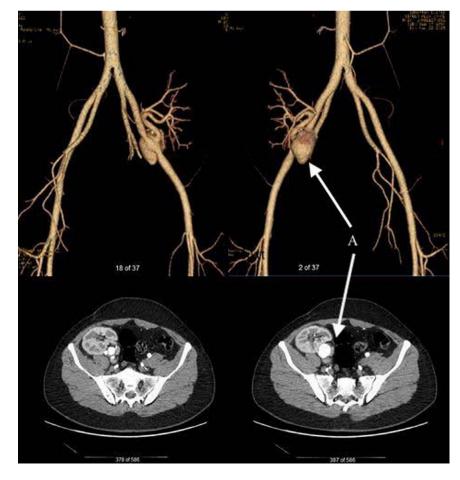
Anastomotic pseudoaneurysm arising on the medial aspect of the end-to-side anastomosis. CT angiography with 3-D reconstruction demonstrates a 4×3 cm sized anastomotic pseudoaneurysm with complete enhancement on arterial phase (labeled A).
